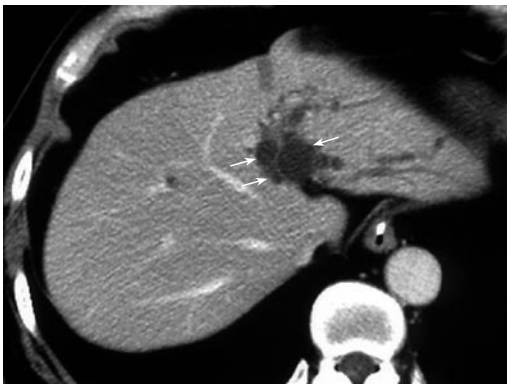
CT revealing multiple small cystic lesions along the umbilical portion of the portal vein (arrows).
